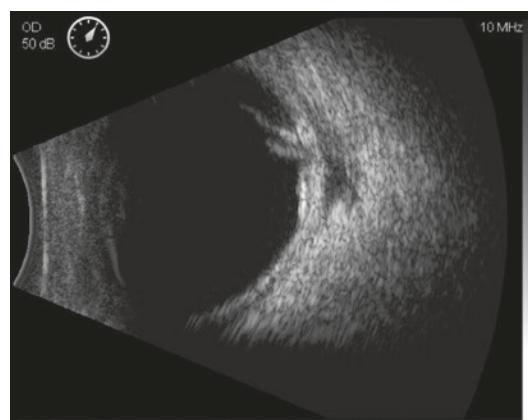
B-scan ultrasonography indicated vitreous opacity, posterior pole ocular wall-penetrating wound, and shallow retinal detachment
